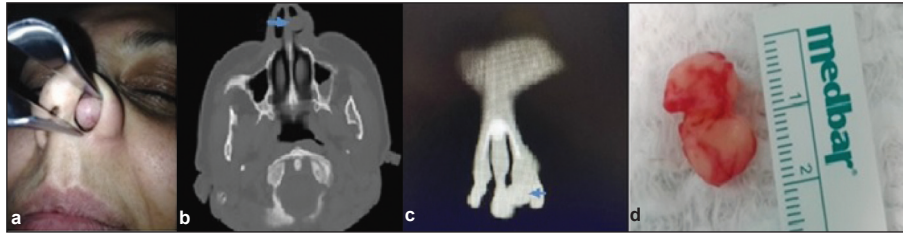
a) Preoperative view of the mass. Preoperative computed tomography imaging (b: Transverse image; c: Coronal image, blue arrow indicates the mass). d) Post-excision view of the mass.
